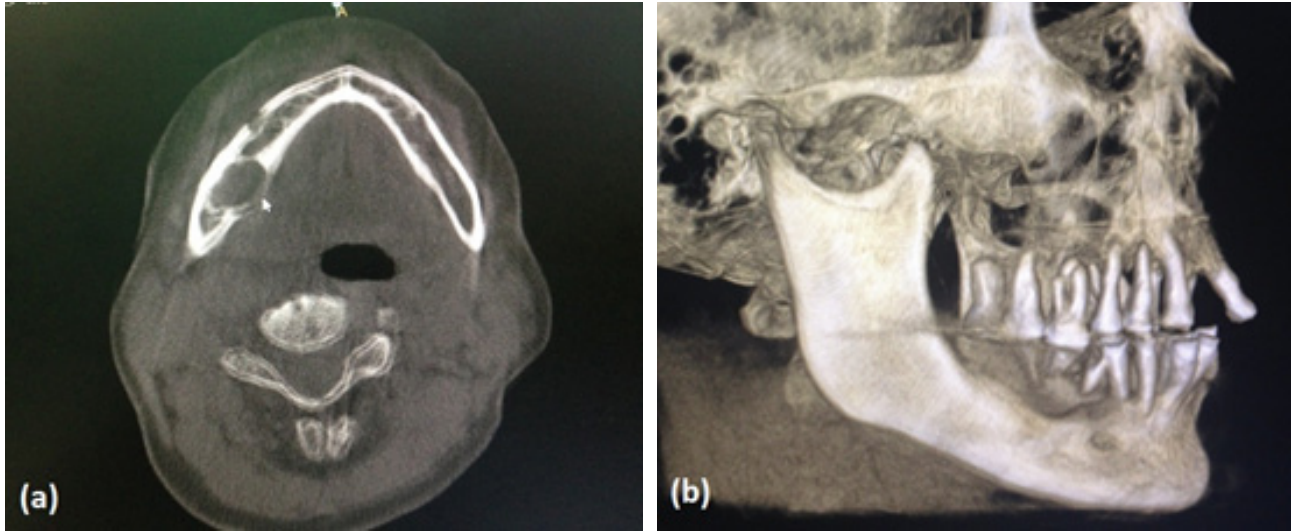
Radiographic presentation (a) axial view (b) 3D reconstruction view.
